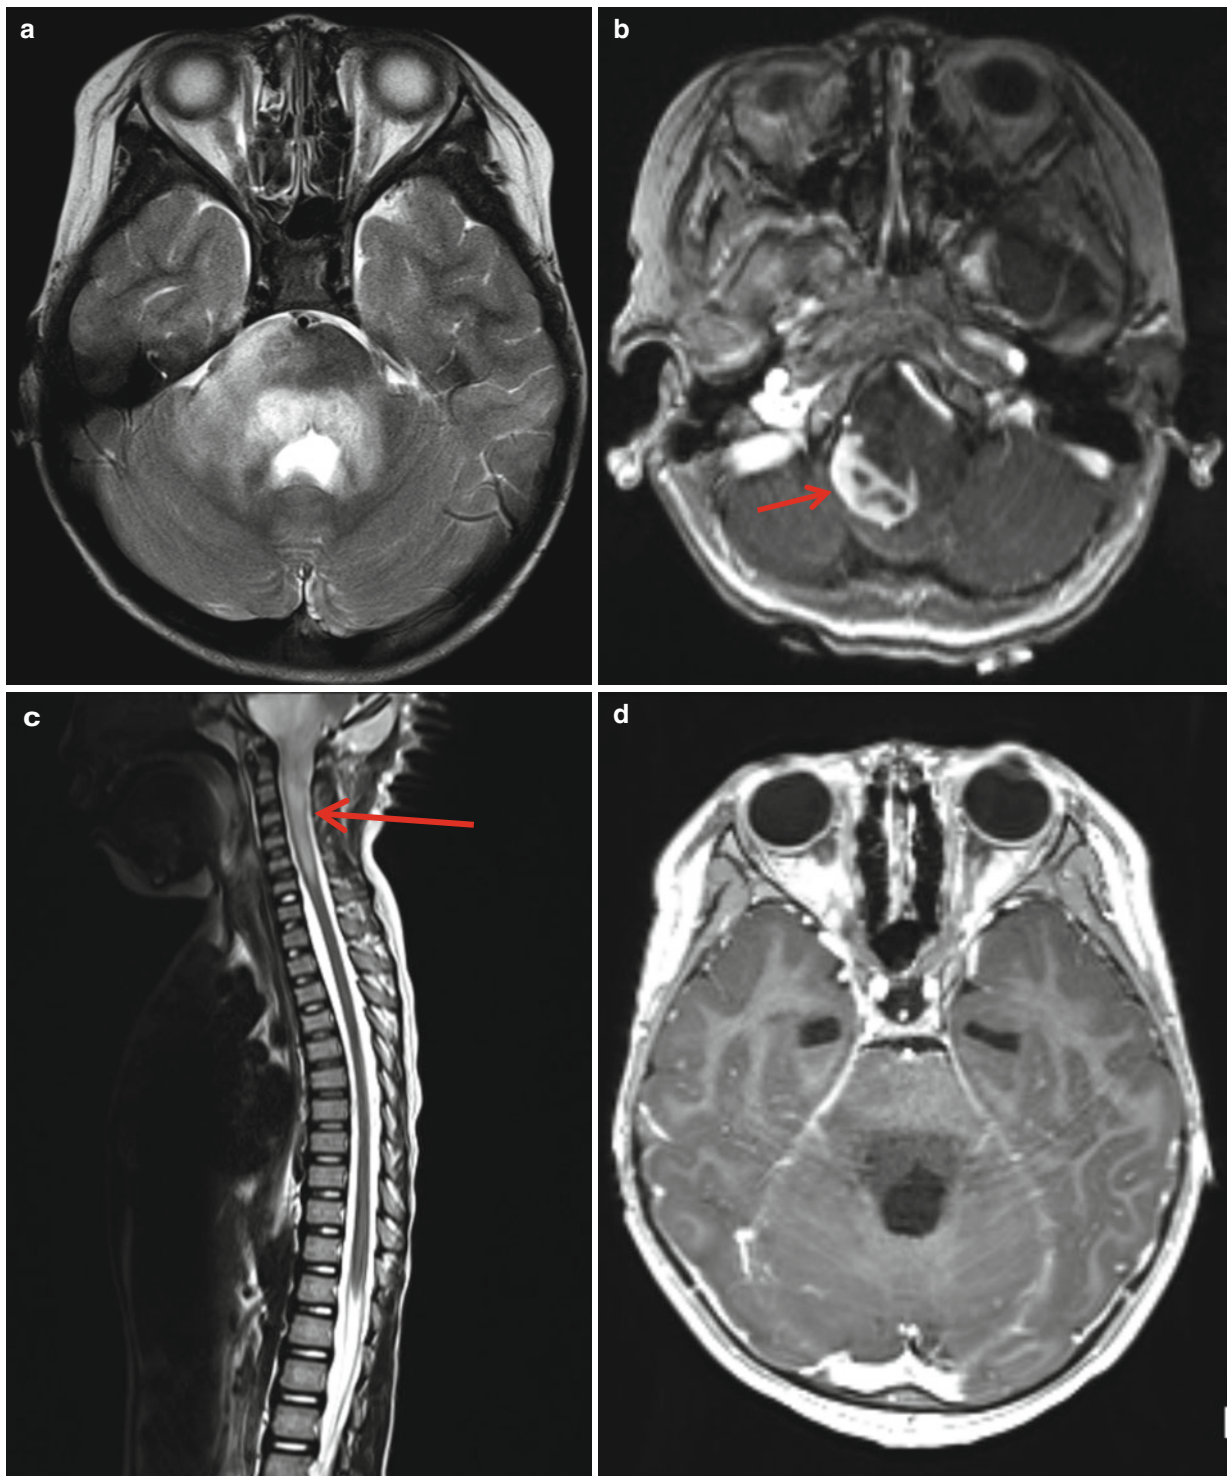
Neuromyelitis optica in a 5-year-old boy with left arm weakness and optic neuritis. (a) T2-weighted image shows right pontocerebellar extensive lesion suspecting tumorous condition. (b) Postcontrast image shows well-demarcated strong enhancement
